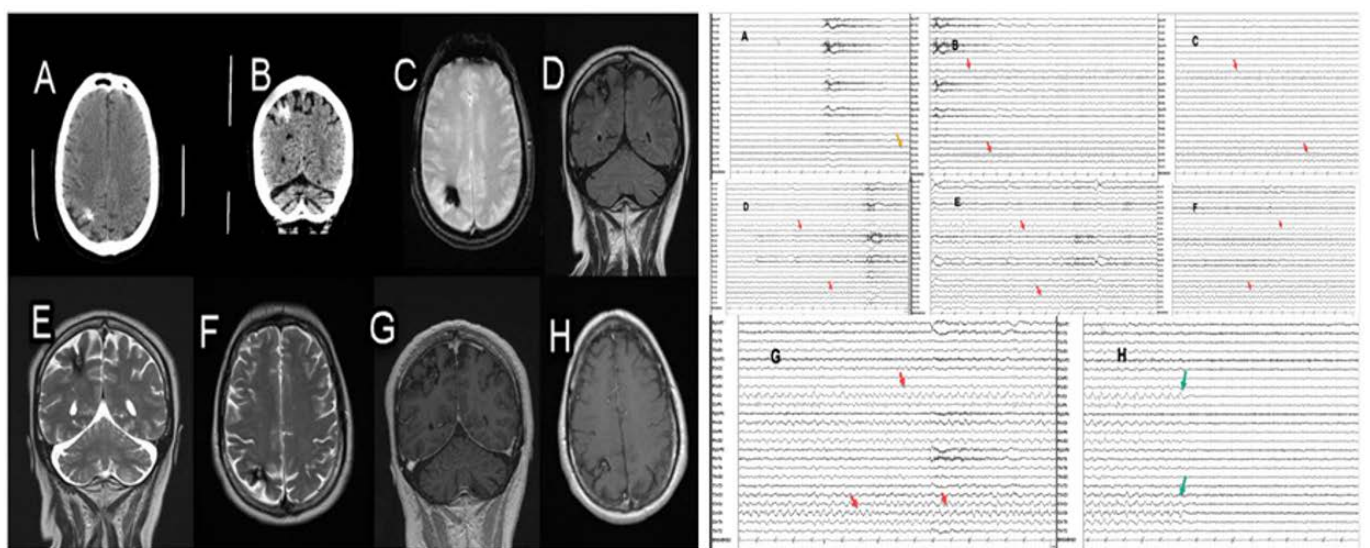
A and B: Axial and Coronal CT imaging. C: Axial gradient echo MRI identifying blood products D : Coronal Flair MRI. E and F: Coronal and Axial T2 MRI. G and H : Coronal and Axial T1 MRI with gadolinium. The imaging series denotes a “pop corn” appearing lesion in the vicinity of the right motor strip with surrounding blood products consistent with a probable cavernoma. A and B panels were obtained approximately 3 years prior to the other panels. EEG identified rhythmic volleys and trains of epileptiform discharges in the vicinity of the noted lesion at C4 with regional spread with concomitant left truncal muscular movements and preserved awareness which were sustained but secondarily generalization occurred on occasion progressing to generalized tonic clonic seizures. Yellow arrows show the onset, Green onset termination of such activity, and Red arrows show various waxing/waning volleys of discharge examples that would recur.
